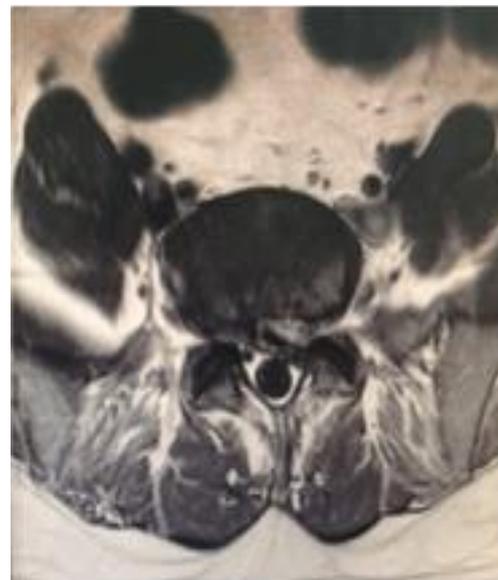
(b). T2-weighted axial view of MRI lumbo-sacral
